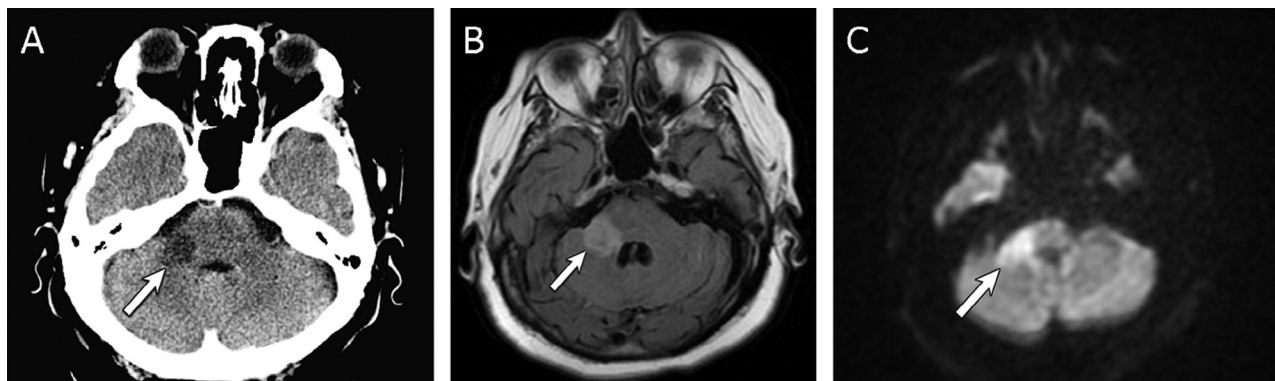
Case 2 presents a 65-year-old female patient with right facial numbness and vertigo. (A) Unenhanced computed tomography of the brain shows hypodensity in the right middle cerebellar peduncle. (B) MRI FLAIR axial image of the brain demonstrates an expansile FLAIR hyperintensity in the right middle cerebral peduncle with (C) mildly increased diffusion-weighted signal with low ADC (not shown), compatible with an acute infarct.
